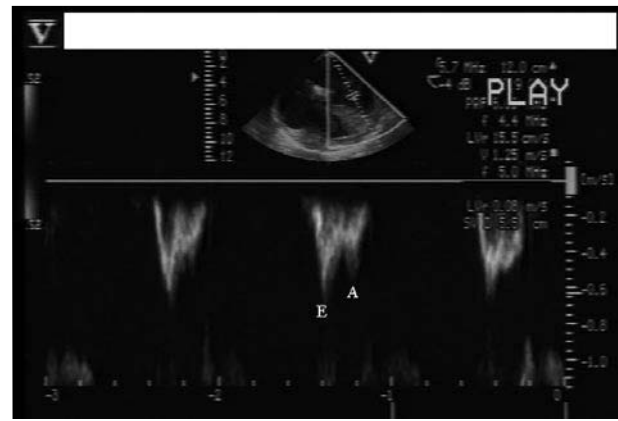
Restoration of mitral inflow pulsed wave Doppler (E: A ratio) with a nitroglycerin infusion during cross clamping.
